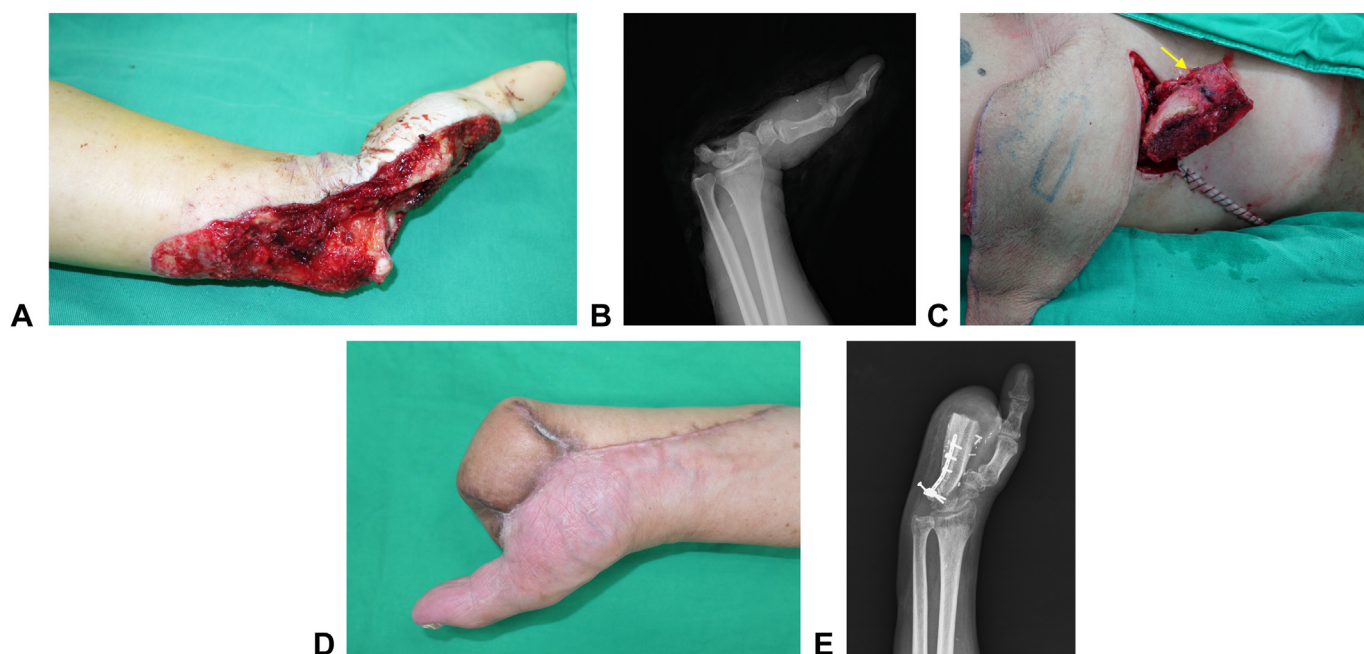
A Left hand crush injury with partial hand amputation, only first ray could be preserved. B Preoperative X-ray. C Pedicled groin flap with vascularized iliac crest based on DCIA (arrow). D, E X-ray and basic hand function at the 1-year follow-up.
